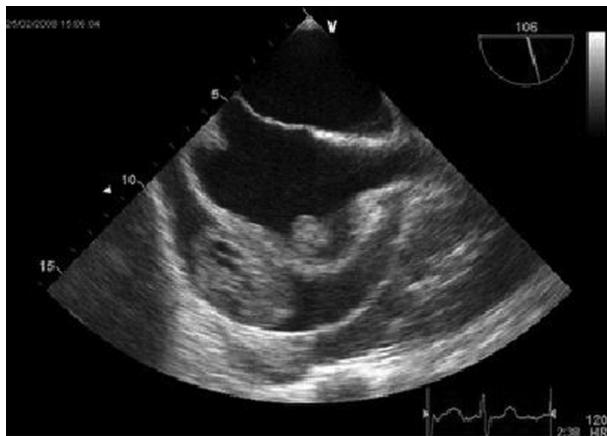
Transoesophageal echocardiography. Large tumour located in the pericardial space infiltrating the atrial wall, also visible in its lumen
